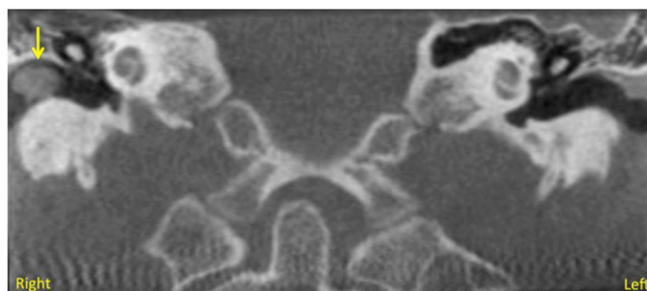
CBCT slice in the coronal plane showing foreign body in the right external auditory canal (arrow).
